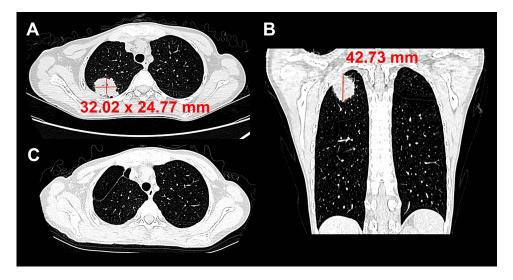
Figure I Chest computed tomography images of the patient before and after wedge resection of the lung lesions. Representative axial (A) and coronal (B) CT scan images revealed a large nodular lesion (32.02 mm × 24.77 mm × 42.73 mm) with a faint surrounding vitreous subpleural located in the right upper lobe. The chest CT scans show no new lung lesions 5 months after the wedge resection (C).
